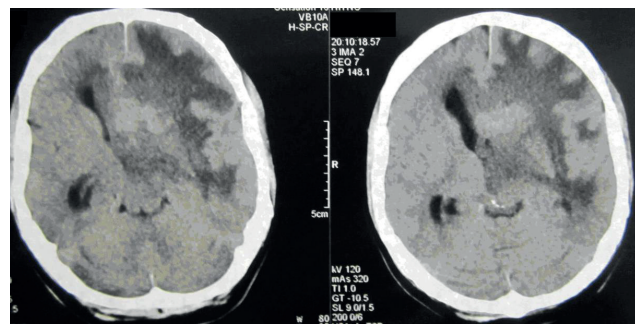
Preoperative CT brain scan revealing intraventricular tumor mass with abundant perifocal edema.
